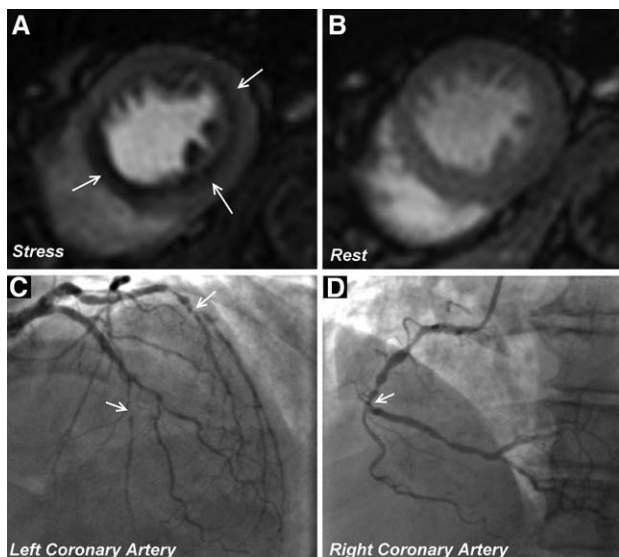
High-resolution perfusion cardiovascular magnetic resonance (CMR) in multivessel disease. A 48-year-old woman with suspected angina underwent stress perfusion CMR at 1.5 T using a high-resolution (1.4 mm in-plane) technique facilitated by 5-fold *k-t* broad linear speed-up technique. Stress-induced perfusion defects were seen in all 3 territories (arrows; A and B) and are clearly demarcated as subendocardial. Subsequent x-ray angiography revealed significant 3-vessel disease (arrows; C and D). This case highlights the ability of high-resolution acquisition to overcome the potential effects of balanced ischemia in multivessel disease by detecting transmural perfusion gradients and subendocardial ischemia.
